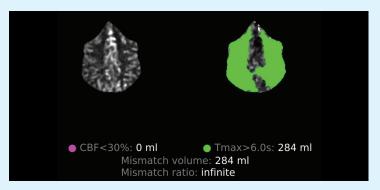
CT perfusion demonstrating significant perfusion delay in both hemispheres
